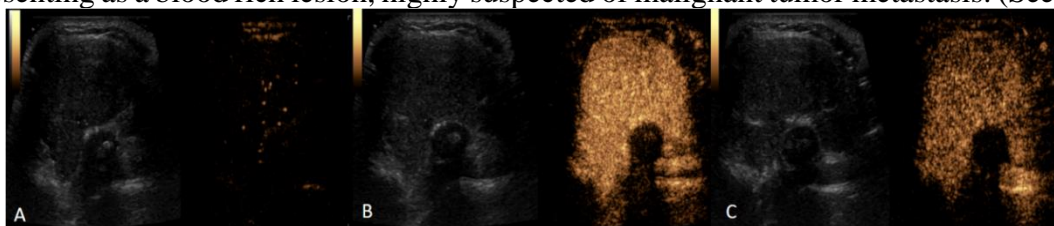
Contrast enhanced ultrasound imaging of right anterior chest wall mass
